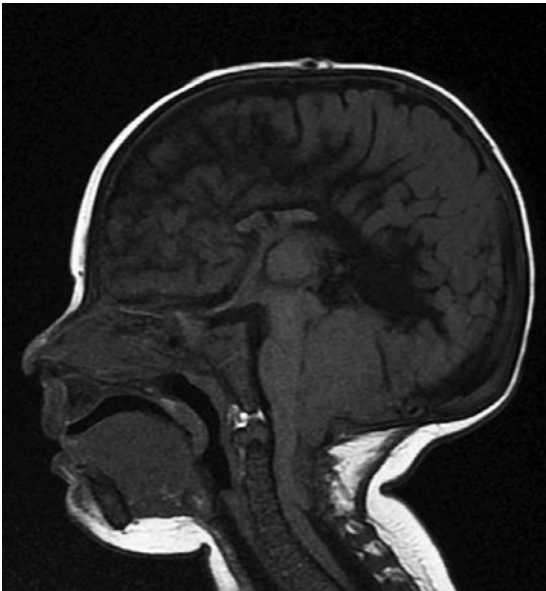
Sagittal magnetic resonance image demonstrating the Chiari II malformation. Note the hindbrain hernia into the neck and small cerebellum. Also note the absence of significant portions of the corpus callosum, a nearly vertical straight sinus, and an enlarged massa intermedia.
